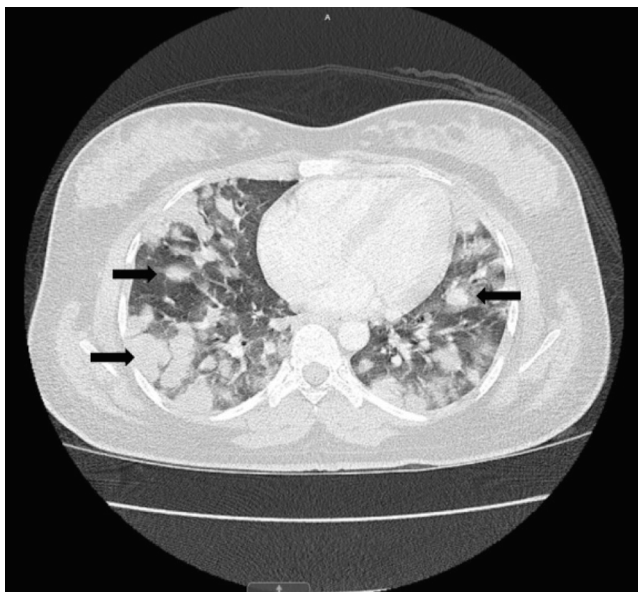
CT scan of the thorax. Innumerable bilateral pulmonary masses (arrows). The masses are mostly spherical, are confluent, and have a random distribution. The masses do not demonstrate cavitation or calcification. No pleural effusion or pneumothorax.
